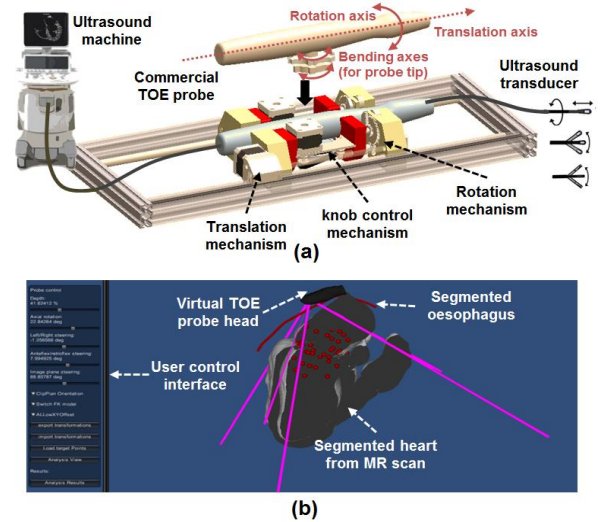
Overview of (a) the robotic 3-D TEE system and (b) the ultrasound view-planning platform.
